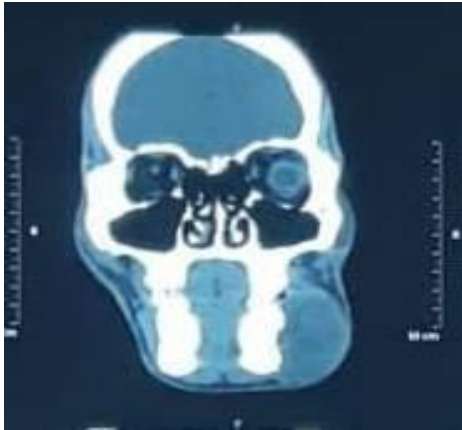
Coronal section of computed tomographic scan showing swelling in the left body mandible
